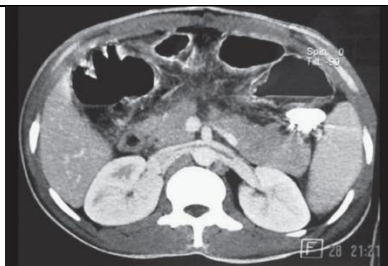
CT Complete Transection of Pancreas
